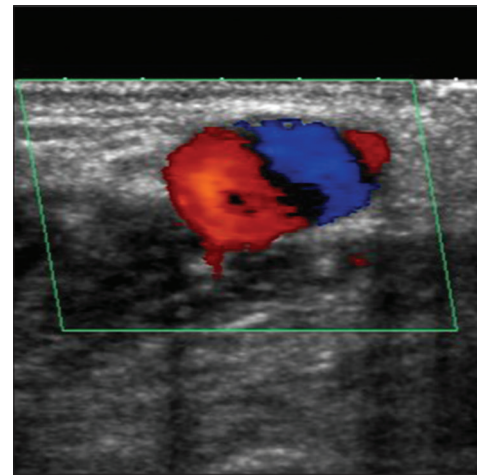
A “Korean flag sign” is observed in color Doppler-mode in an aneurysm of the forearm cephalic vein of a hemodialysis patient
